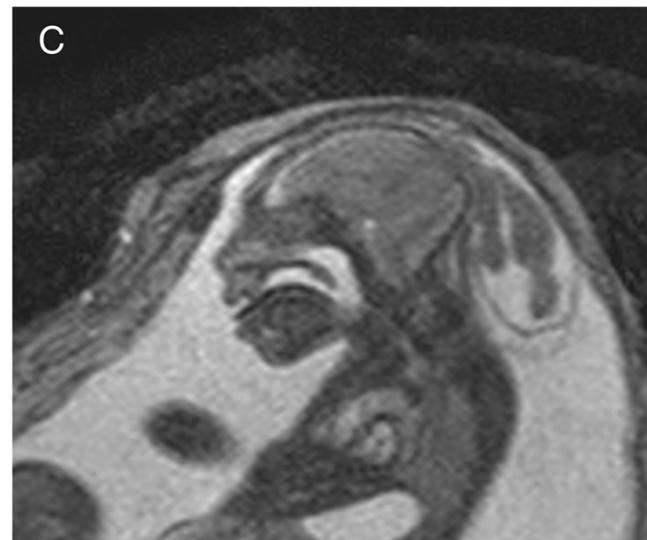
Sagittal T2-weighted MRI of a fetus at 22 weeks gestation demonstrates a large parieto-occipital cephalocele with herniation of significant parts of the bilateral parieto-occipital lobes and global microcephaly.
